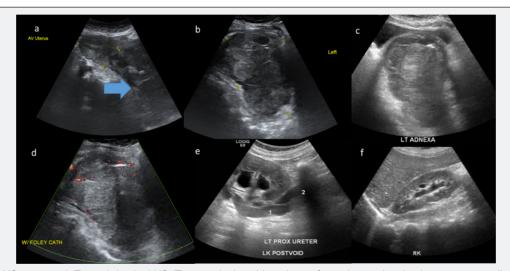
First US requested: Transabdominal US (Transvaginal could not be performed as patient having mass protruding in to vagina): Part of uterus seen in (Image a) with normal endometrial cavity. Large mass seen from utero-cervical region extending down (large arrow in image a) and more towards left adnexal region appears heterogeneous (image a,b,& c). Color Doppler exam reveal minimal internal vascularity. Patient having catheter in urinary bladder and is collapsed. Left hydro nephrosis and hydro ureter seen indicating invasion of left distal ureter (image e). Minimal right hydro nephrosis with no hydro ureter. No liver lesion (images not shown).
